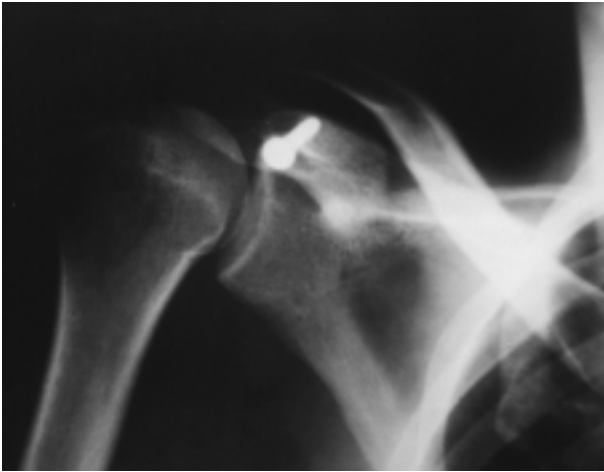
Postoperative xray showing reattachment of the coracobiceps musculotendinous flap.
